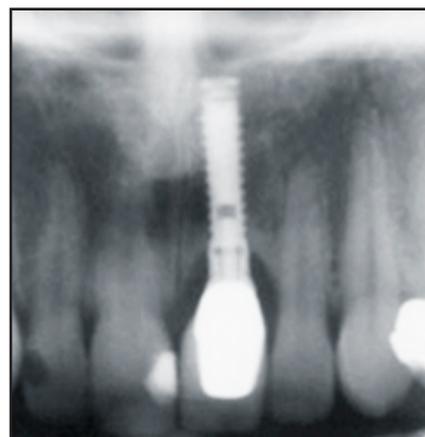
Radiographic view of left anterior central incisor, 10 years postrehabilitation.
